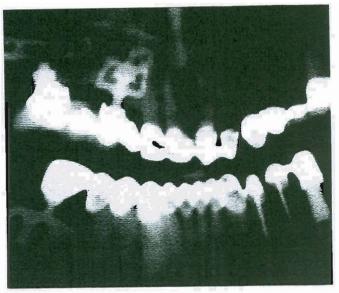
Case 5: Seven-year post-operative Panorex showing no radiographic changes of the blade implants in the grafted site. A root-form implant was used to replace the left mandibular 1st molar, which fractured at root bifurcation three years after the Panorex in Fig. 40 was taken.
